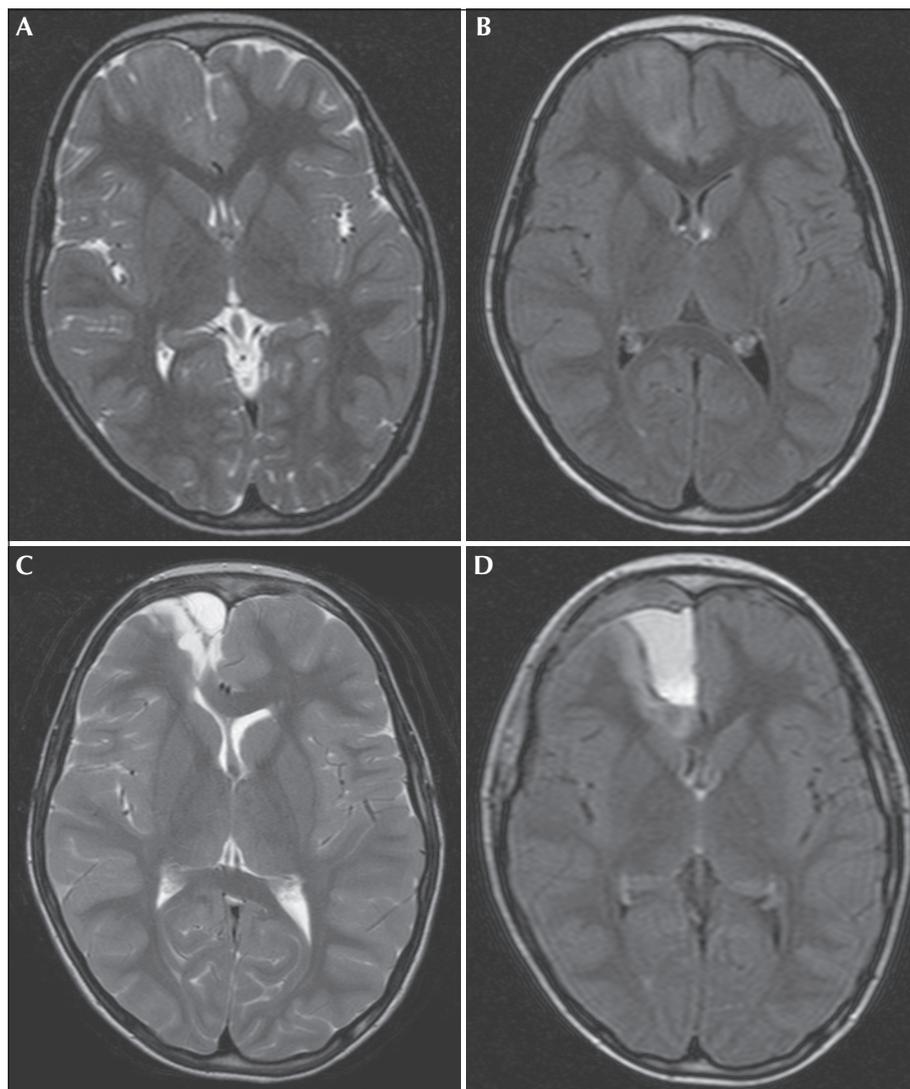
High-resolution MRI (transversal plane) of the patient. (A) T2-weighted and (B) FLAIR images. Increased cortical thickness, hyperintense cortical signal changes, and blurred grey/white matter junction, changes typical of FCD, localised to the medial orbitofrontal gyrus and frontal pole with extension to the anterior cingulate gyrus, rostral cortex and caudal and mesial parts of superior frontal gyrus. (C, D) Postoperative MRI; complete resection of the lesion was confirmed.
